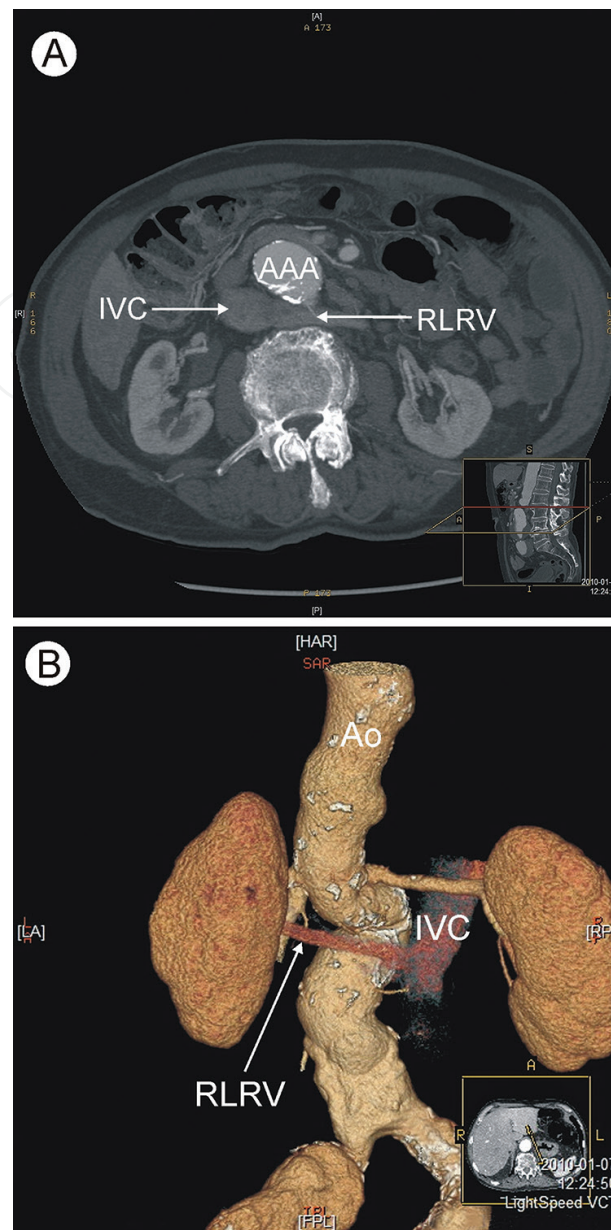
Computed tomography investigation of the abdomen with retroaortic left renal vein (CT-64-row MDCT scanner, Light-speed VCT, GE, Waukesha, Wisconsin, USA). (A) Transverse scan on L2 level, (B) three-dimensional computed tomography reconstruction of the vessels (posterior view). Ao: aorta, AAA: abdominal aortic aneurysm, IVC: inferior vena cava, RLRV: retroaortic left renal vein.
